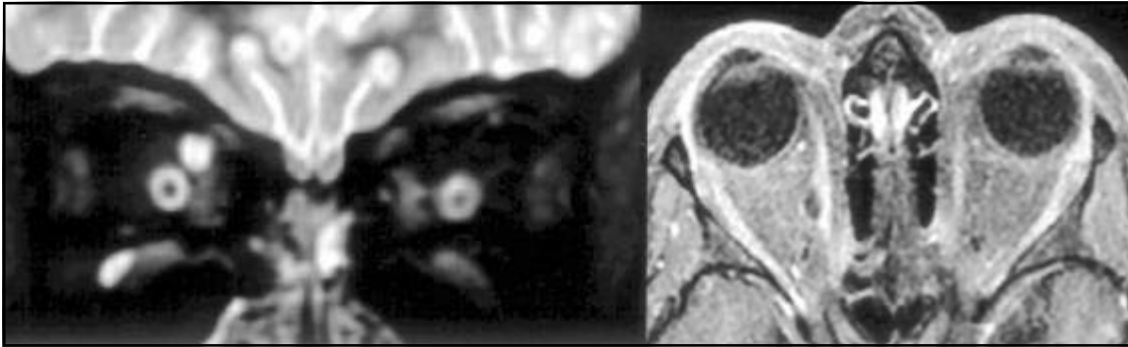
MRI Coronal T2WI and Axial T1WI with Fat saturation postcontrast (Gd-DTPA). Small cystic lesion in the right medial rectus muscle.
